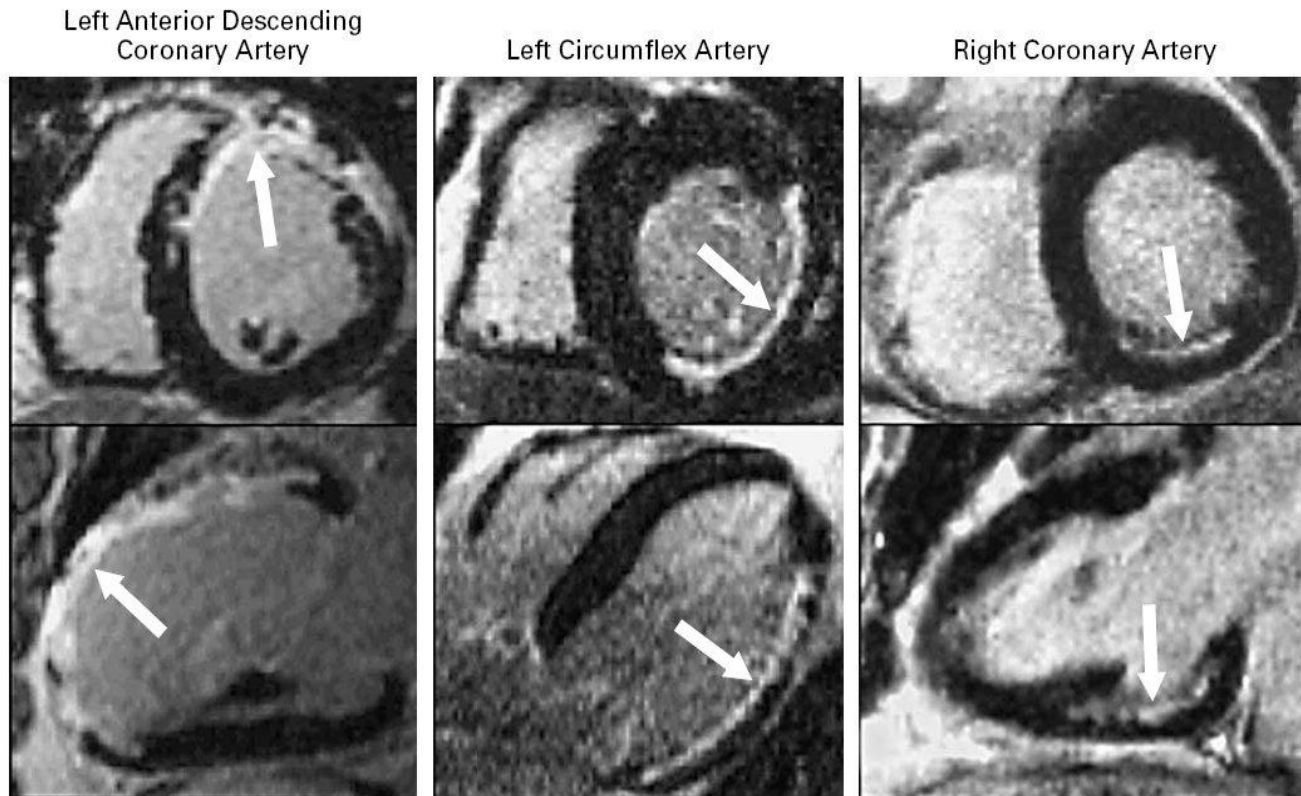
Typical Contrast-Enhancing Images Obtained by MRI in a Short-Axis View (Upper Panels) and a Long-Axis View (Lower Panels) in Three Patients.
